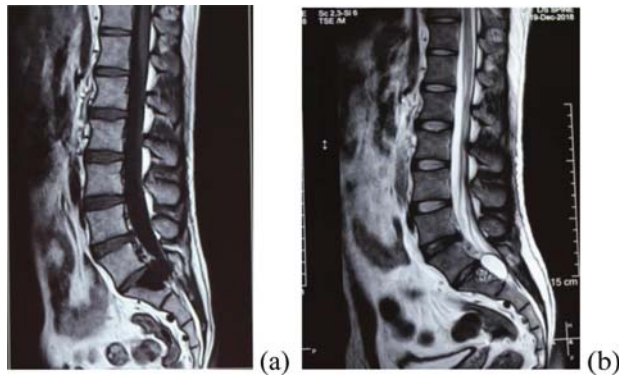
(a) and (b) showing the sagittal MRI of lumbo-sacral spine with extradural cystic lesion in the postero-left lateral aspect of sacral spine causing erosion of the adjacent bone
